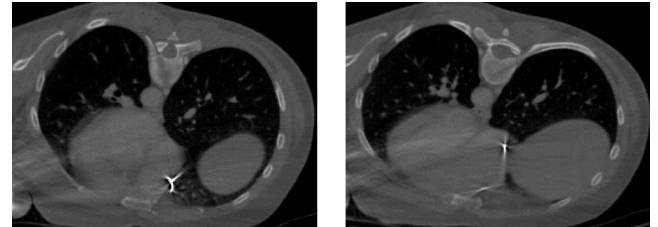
Hyperdense foreign bodies in the middle mediastinum on axial computed tomography images
